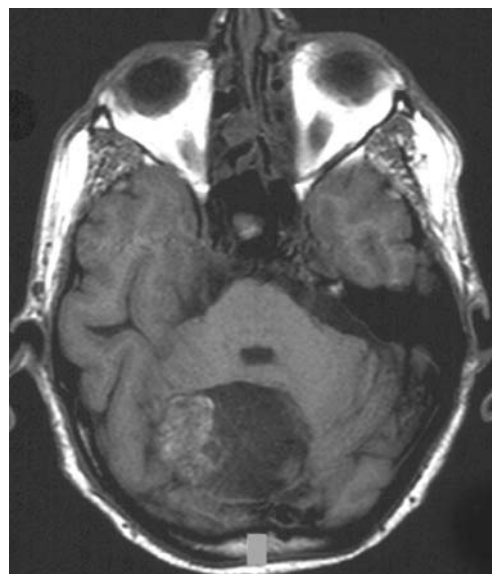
Axial MRI (T1-WI) with mainly hypointense and laterally non-homogeneously iso- to hyperintense signal of dermoid (Patient 4)
